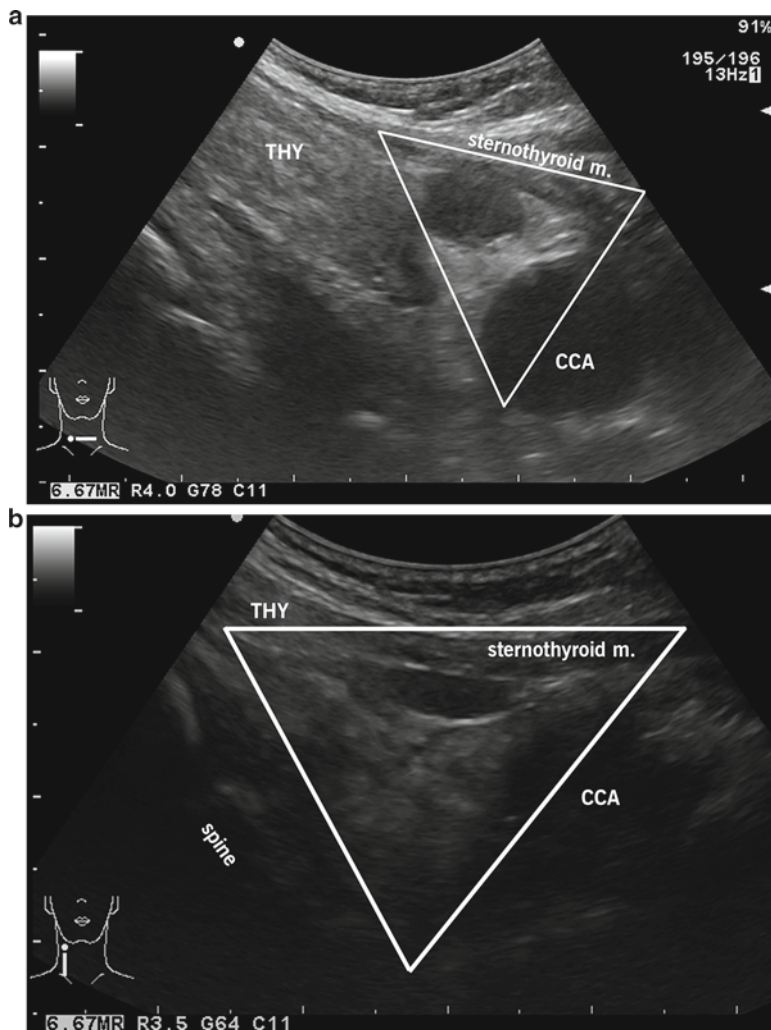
The “triangularization” of the central neck is a view in the longitudinal ultrasound plane that helps define a space where abnormal inferior parathyroids reside. The outlines of the triangle are the sternothyroid muscle, a line paralleling the spine to reach the lower pole of the thyroid gland, and a line across the sternal notch, or in example A, the cross section of the common carotid artery (CCA). The hypoechoic density contained within this triangle is an inferior parathyroid adenoma. Note also
